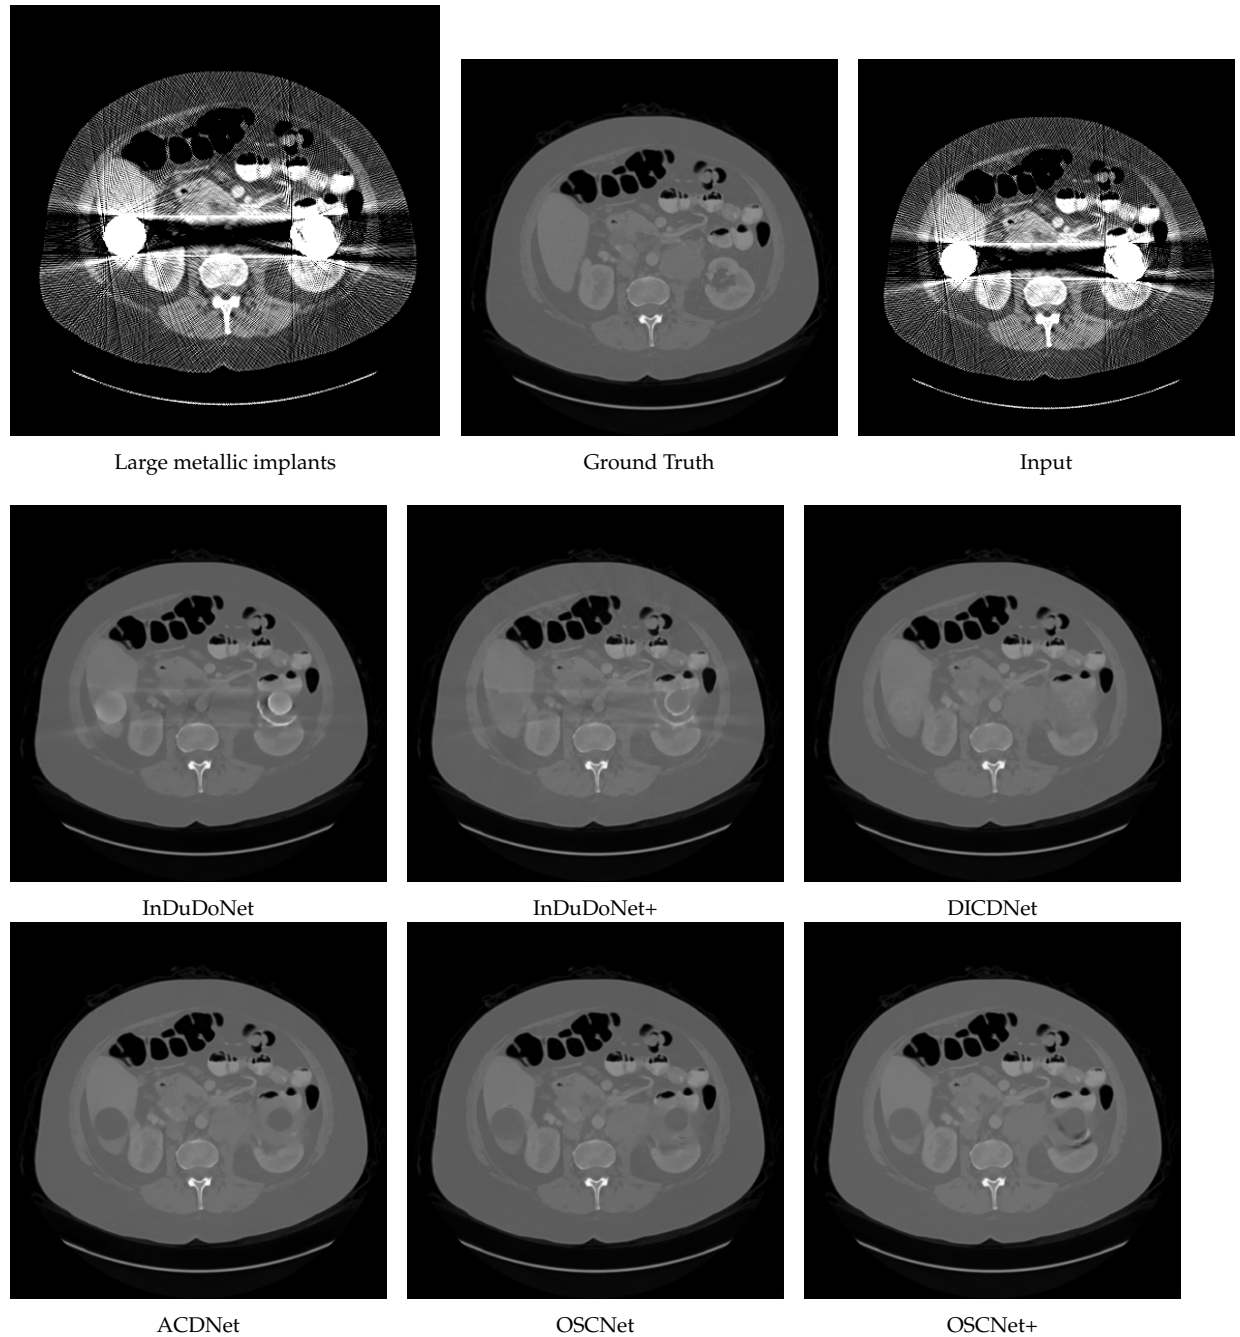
Closer investigation of reconstructed images of large metallic implants. The metal-corrupted CT images is from the synthesized DeepLesion dataset.
